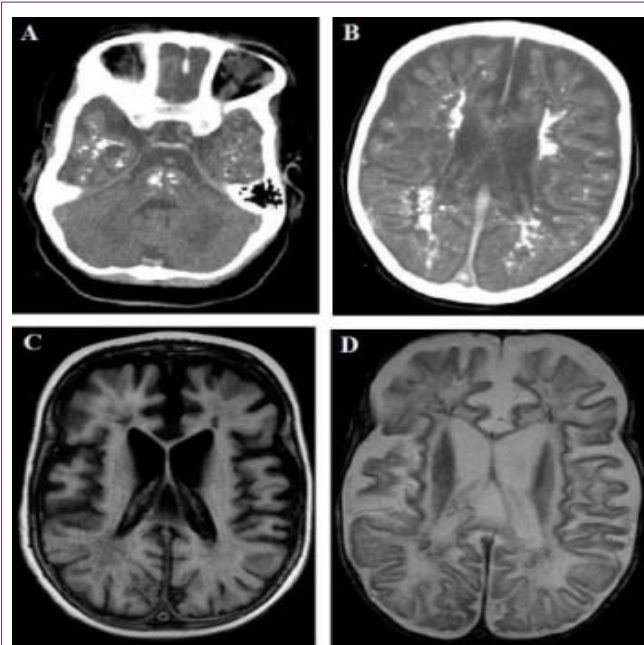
(A and B) Axial CT non-contrasted images showing multifocal supra- and infratentorial calcifications associated with a severe cortical and subcortical atrophy, indicating brain injury due to chronic venous hypertension. (C and D) T1 FSE (A-D) and T2 gradient-echo (T2* E-H) MR sequences on an axial plane, showing evident atrophy due to venous hypertension resulting in brain destruction. Note faint hypointensities on T2* corresponding to parenchymal calcifications.
